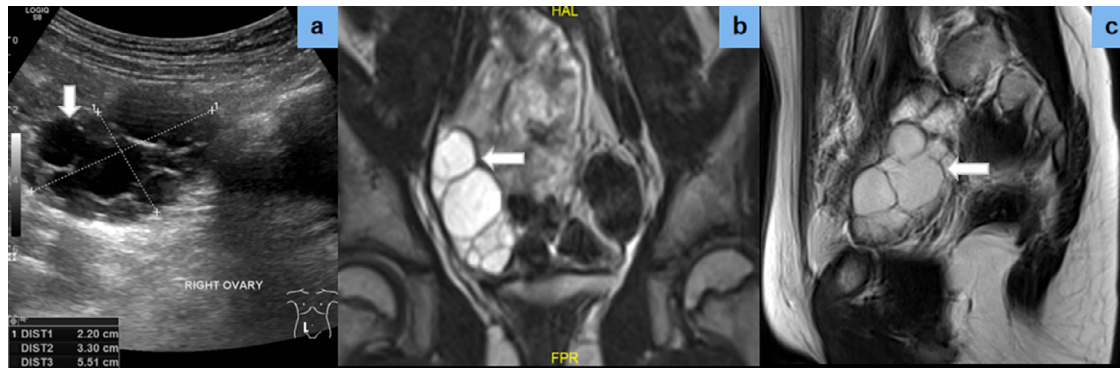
Abdominal ultrasound (a) showed a multilobulated cystic mass (arrow) of the right ovary, containing many regular septa. Similarly, the T2-weighted (T2W) coronal (b) and sagittal (c) magnetic resonance imaging (MRI) revealed a homogeneous cystic mass without a hemorrhage component, solid pattern, or papillary projection.
